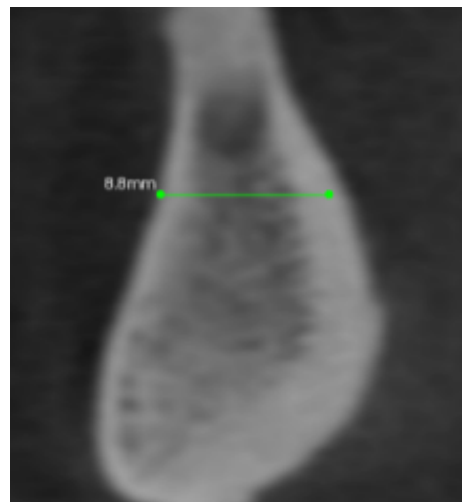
Pre-operative CBCT assessment showing adequate bone volume in the intra-foramina region for implant placement. The severe resorption of the mandible has led to the mental foramina sitting on the crest of the ridge. Great care must be taken to avoid neurosensory disturbance.
